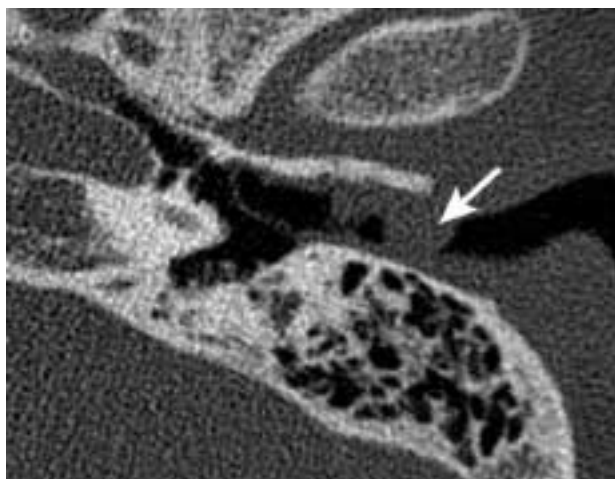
High-resolution CT-scan of the left temporal bone. It shows a soft tissue mass (arrow) in the left external auditory canal.
